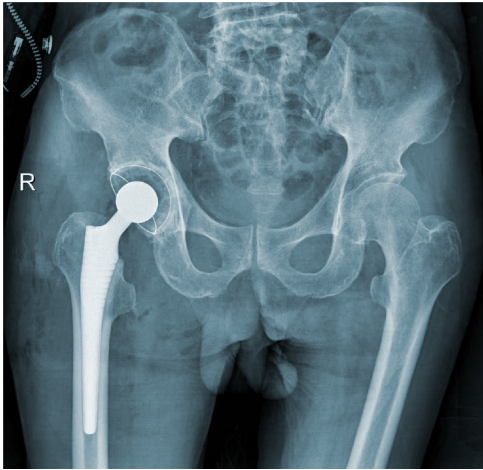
Right hip X-ray film after total hip arthroplasty.
